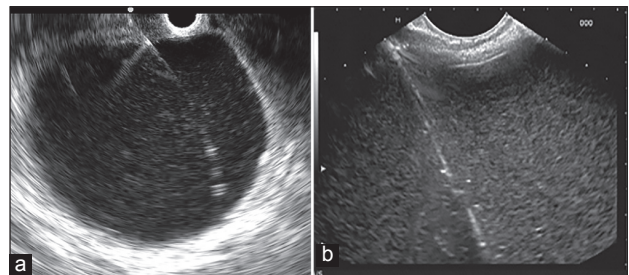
(a and b) The guide wire being pushed into the pseudocyst cavity under endoscopic ultrasound guidance
